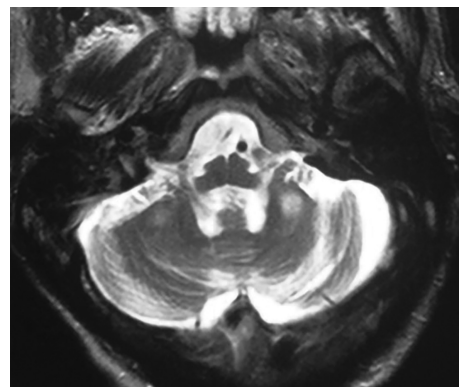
MCP sign on axial T2-weighted MRI, referring to hyperintensity in the middle cerebellar peduncles, most commonly seen in fragile X-associated tremor/ataxia syndrome (FXTAS).
